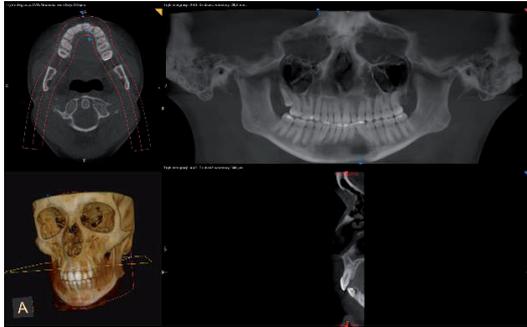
CBCT performed with CS 9300
